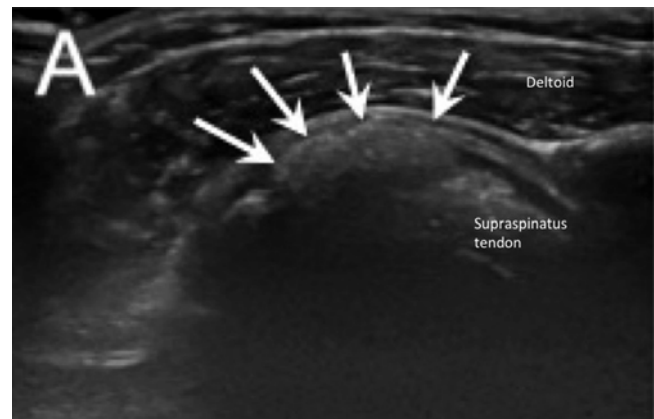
Sonography of the calcium deposit in soft calcific phase. The *arrows* indicate the calcification. Note the minimal echogenic shadow cast by the calcium (Reproduced with permission from Philip Peng Educational Series)
